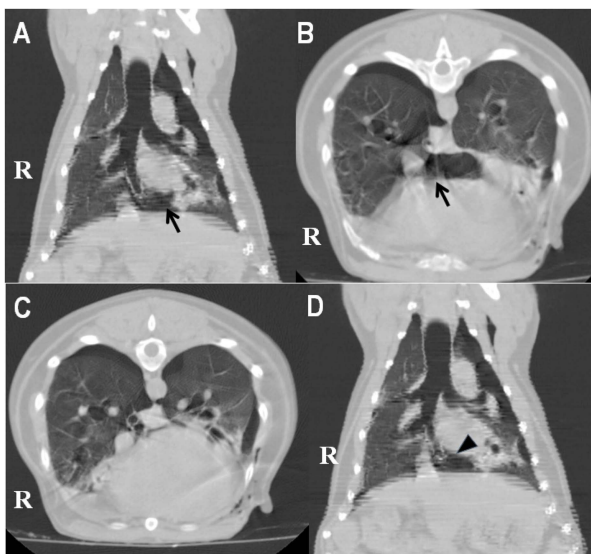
Dorsal (A, D) and transverse (B, C) CT images. Note the air-filled cyst (arrow head) suspected and collapsed lobe with abnormal shape of bronchus (arrows) at the accessory lobe.
